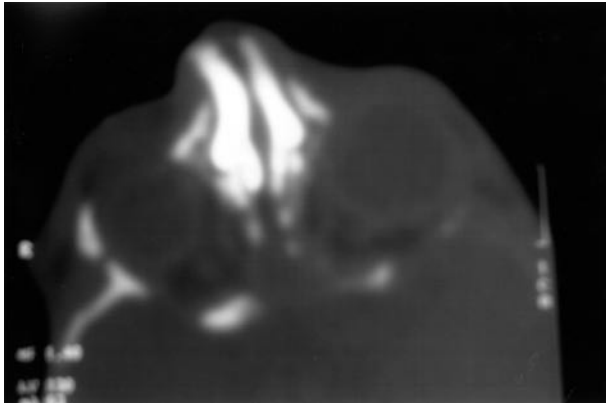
Contrast CT nasopharynx: bilateral choanal atresia
